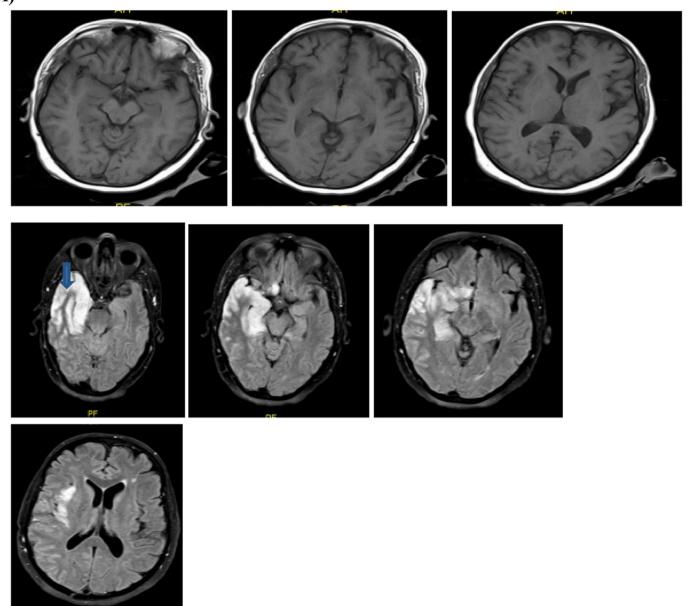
a,b: Axial brain MRI show an ill-defined (predominantly cortical) area of abnormal signal intensity involving the right temporal lobe, right hippocampus, the posterior portion of right gyrus rectus and right insula, being hyperintense at both T2WI and FLAIR, hypo-intense at T1WI, with gyral swelling and diffusion restriction (prominent at insular region) with positive mass effect in the form of effacement of ipsilateral cortical sulci and sylvian fissure. Sparing of the right basal ganglia structures is seen. The left hippocampus also shows a subtle area of increased T2/FLAIR signal, with no diffusion restriction. Left fronto-parietal small white matter foci of abnormal signal being hyperintense at both T2 and FLAIR WI, isointense at T1WI, shows no diffusion restriction, no significant mass effect or perilesional edema. Post contrast study revealed subtle patchy enhancement of the involved region, associated with mild linear lepto-meningeal enhancement extending to the adjacent portions of the right parietal lobe.
